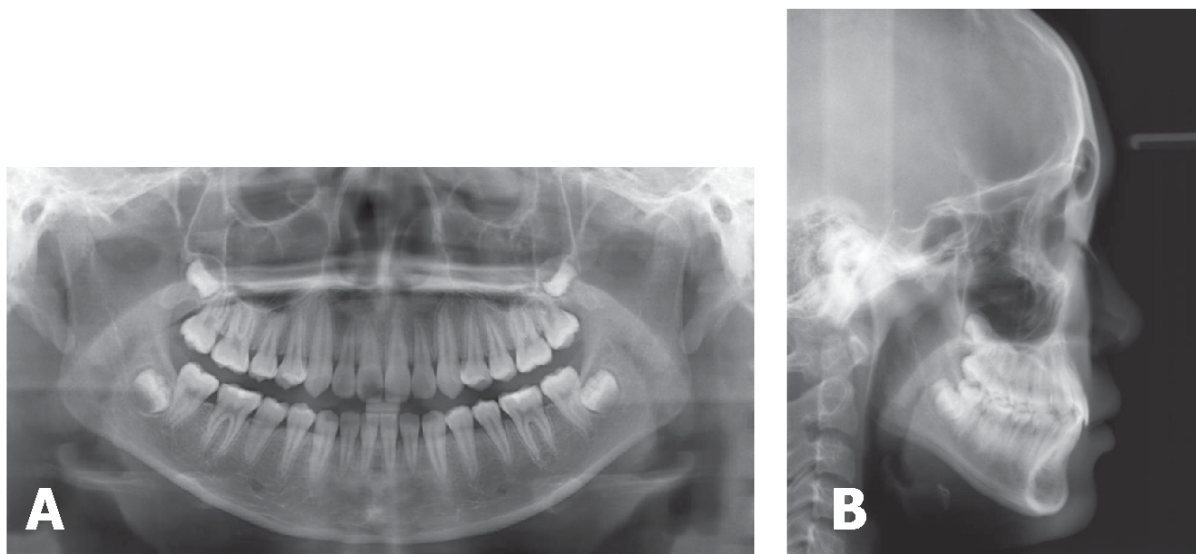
Posttreatment radiographic views: A. Panoramic view; B. Lateral cephalometric view.
